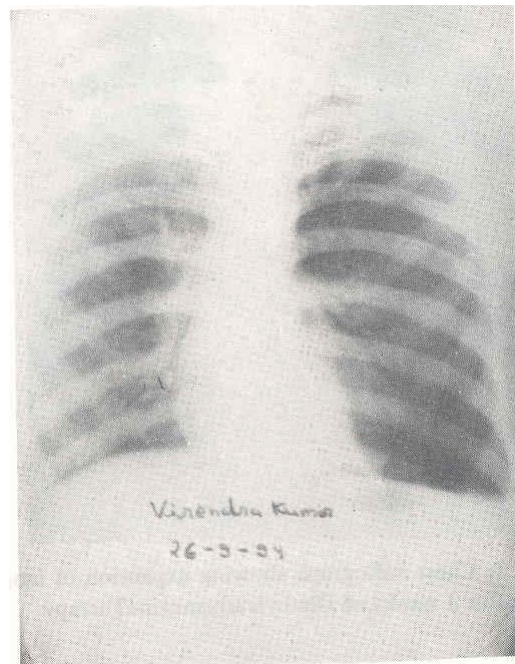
Chest radiograph showing hydropneumothorax on left side
